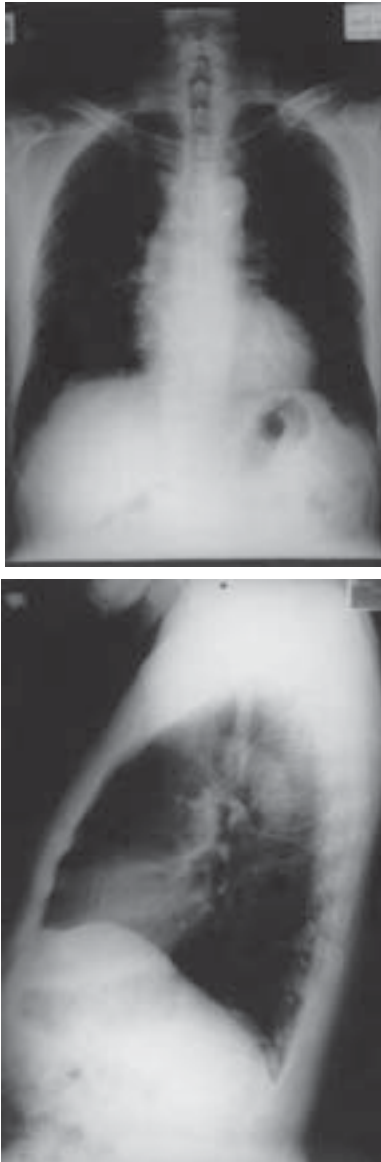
Follow-up chest x-ray 5 months after treatment showing significant improvement. The mass at the right tracheobronchial tree was disappeared.
